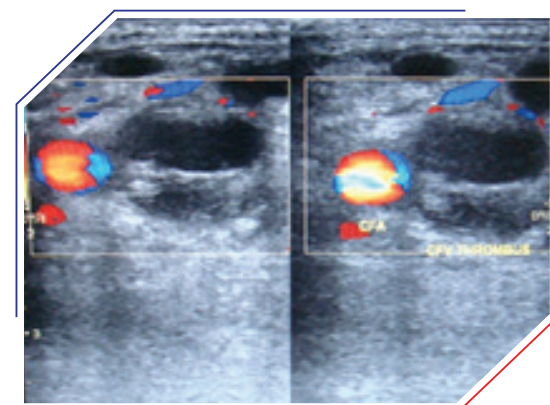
Colour doppler outlining the thrombus
